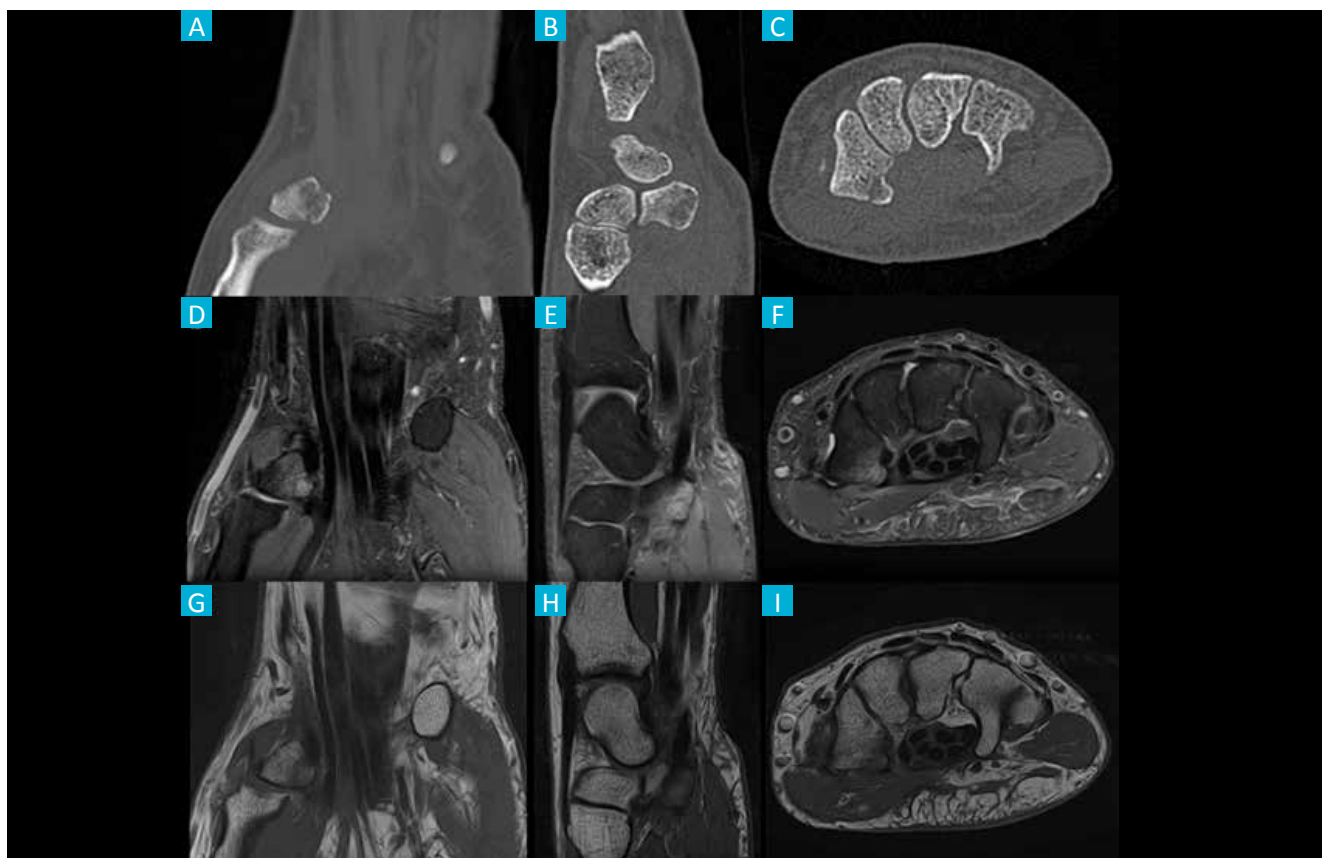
Left hand computed tomography scan (A - coronal, B - sagittal and C - axial views) and magnetic resonance imaging (D - coronal DP FS, E - sagittal DP FS, F - axial DP FS, G - coronal T1, H - sagittal T1 and I - axial T1) showing a non-displaced small volar fragment of the trapezium.
